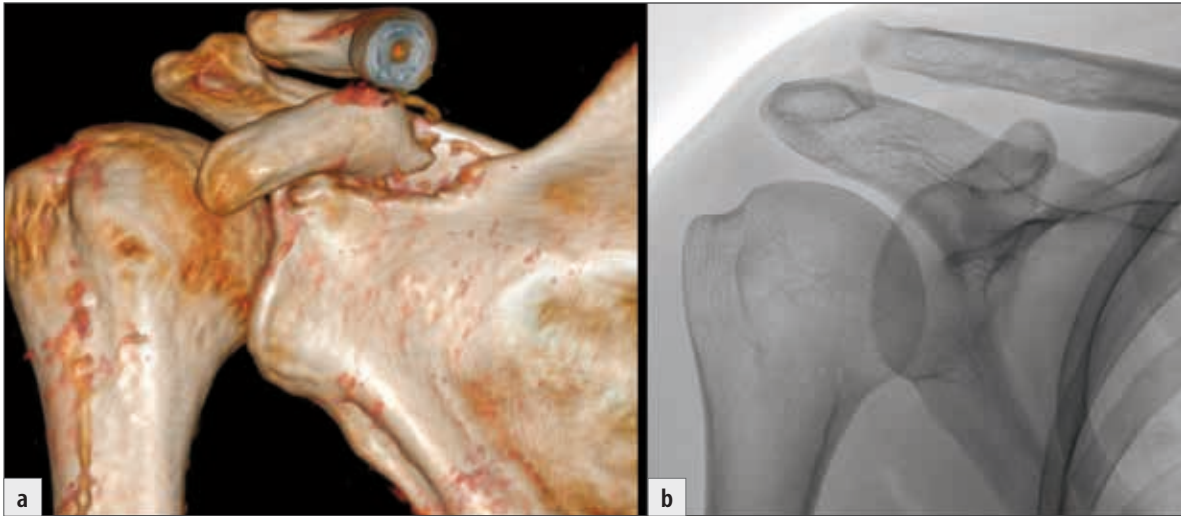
Osseous extraarticular AC instability associated with a coracoid base fracture: a) 3D CT reconstruction; b) radiograph.
